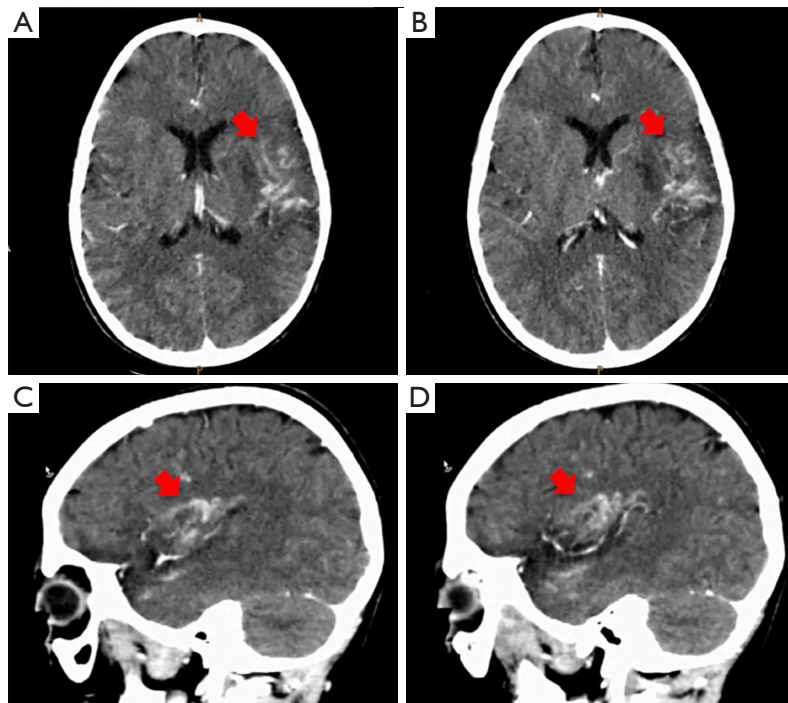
Computed Tomography of the brain with contrast (transverse section A and B, sagittal section C and D). Arrows show centripetal and centrifugal reinforcement at the knee of the internal capsule, lenticular nucleus, external capsule, insula lobe, and temporal lobe; the area of involvement is the left middle cerebral artery.
